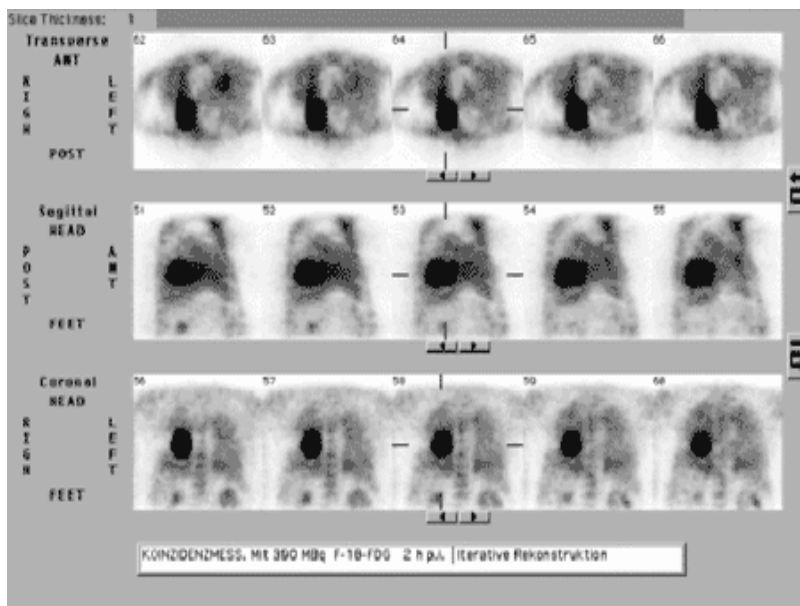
Coincidence PET imaging (E.CAM duet) with F-18 FDG in a patient with a non-small cell lung cancer. Intense uptake in the tumor in the right lung.
